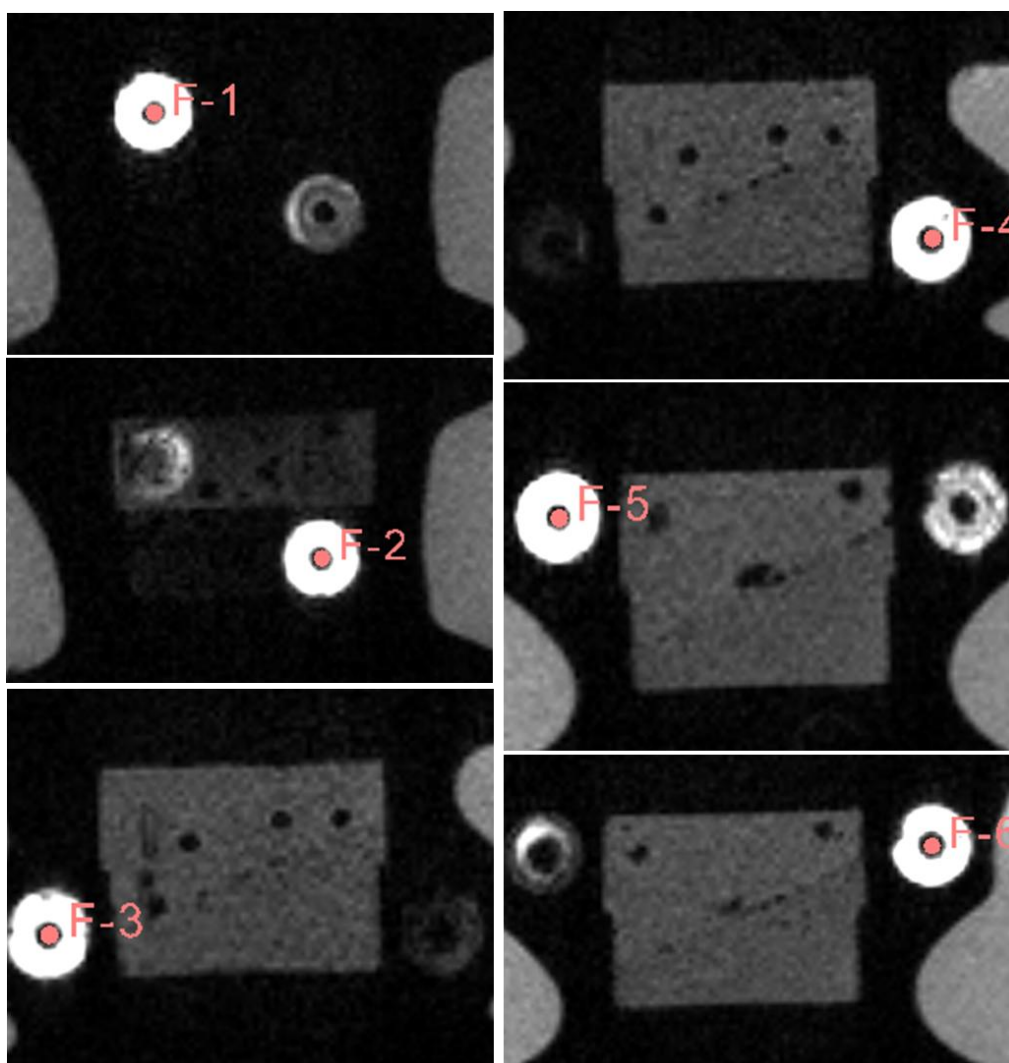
In Slicer, fiducial points were selected at the center of the multi-modality radiology disk-shaped markers visible in the MRI DICOM images.
